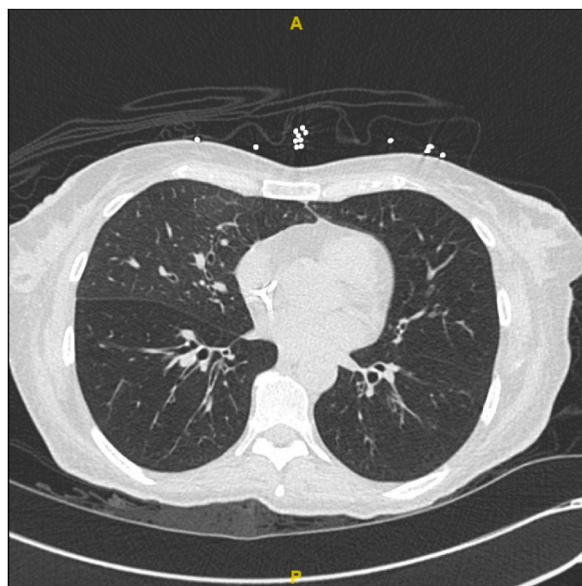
Axial slice from Computed Tomography of Chest demonstrating mosaicism and bronchial wall thickening.
